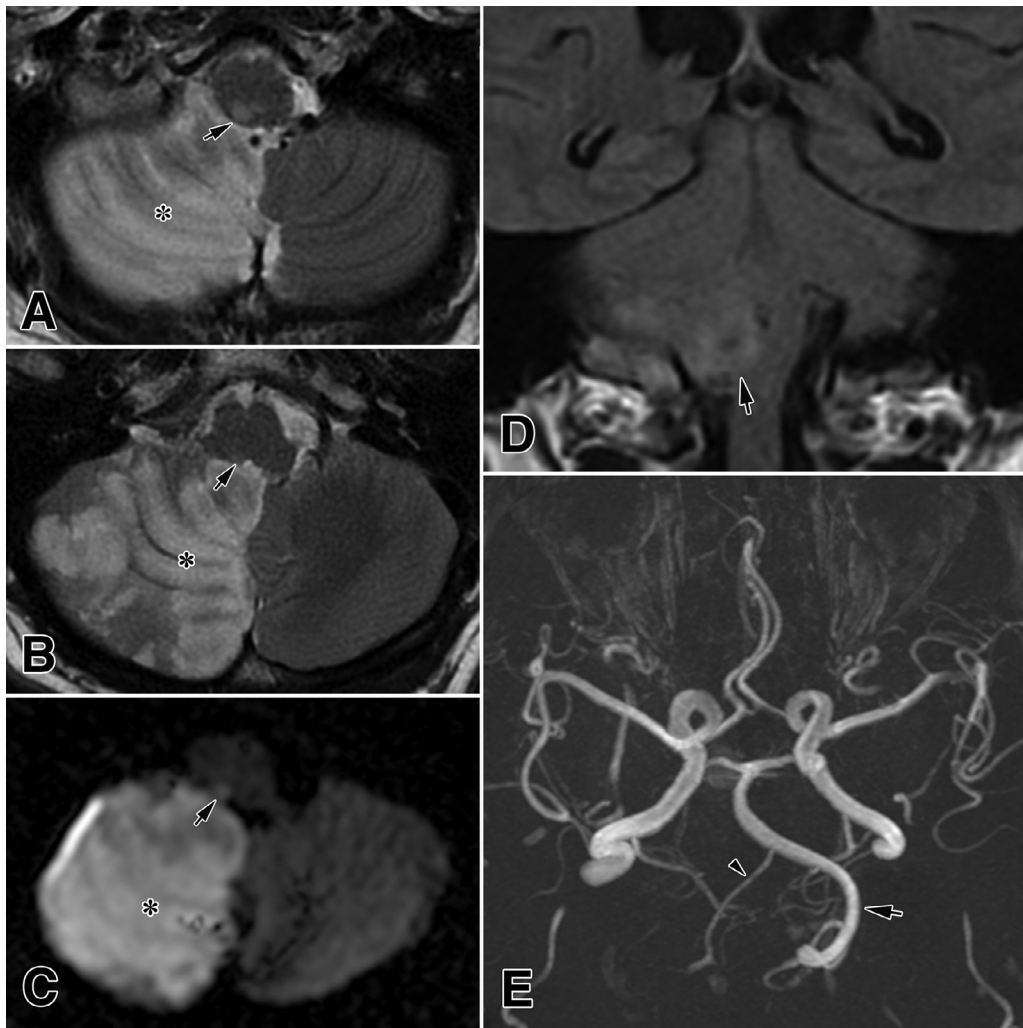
A right dorsal medial infarction (arrows) of the middle and upper medulla in the axial T2-weighted (A and B) and DWI (C) images, and in the coronal FLAIR (D) and sagittal T2-weighted sections (D). Note the MRA (E) of a dominant vertebral artery (arrow) and a very hypoplastic right VA (arrowhead). Also note a cerebellar infarction of the right hemisphere (asterisks) (A–D). The MRI was performed 5 days after onset.
